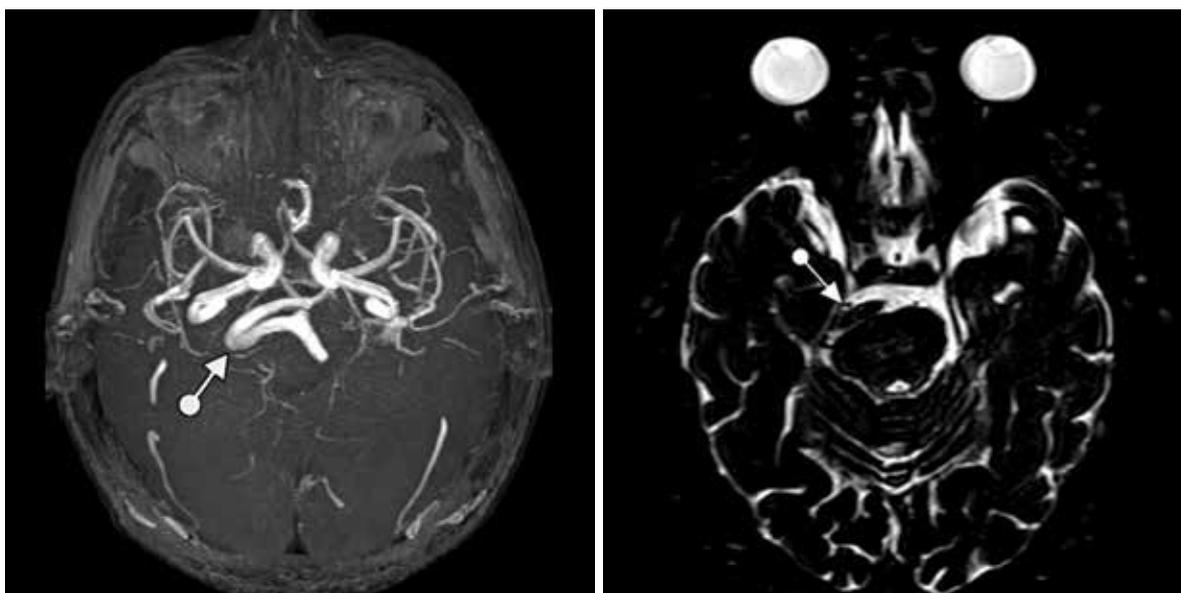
Vertebrasilar dolichoectasia (arrow) on brain MRI
